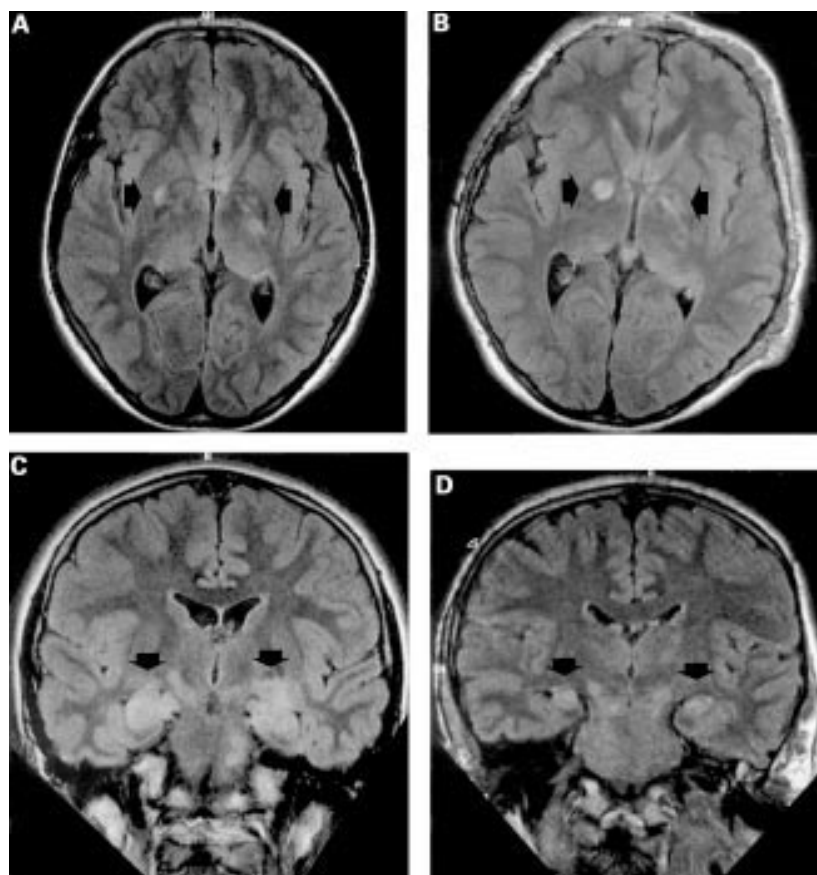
(A) and (B) show flare sequence axial MRI of twin 1 and twin 2 respectively demonstrating virtually identical lesions in the region of both internal capsules highlighted with arrowheads. (C) and (D) show flare sequence coronal MRI scans of twin 1 and twin 2 respectively through the temporal lobe regions showing high signal changes in the hippocampi bilaterally (highlighted with arrowheads) more marked in twin 1 than twin 2.
